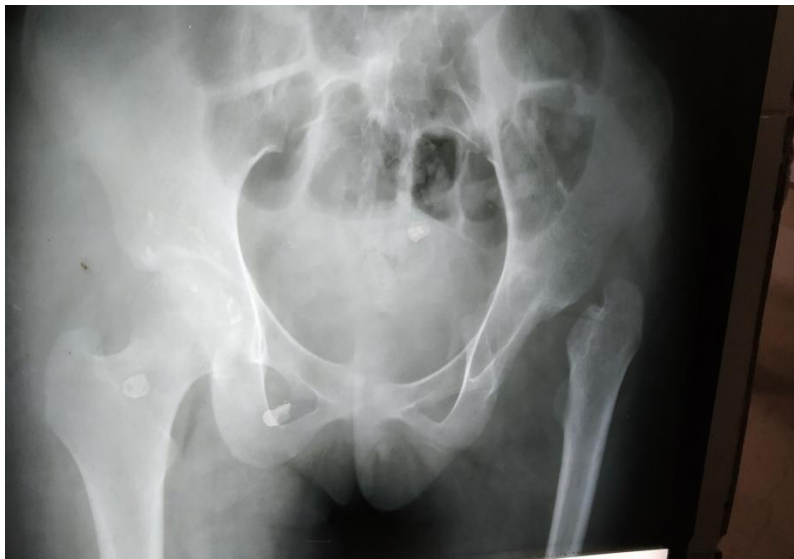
The x-ray of the pelvis after the first operation, showing post Girdlestone osteotomy and skeletal traction.
